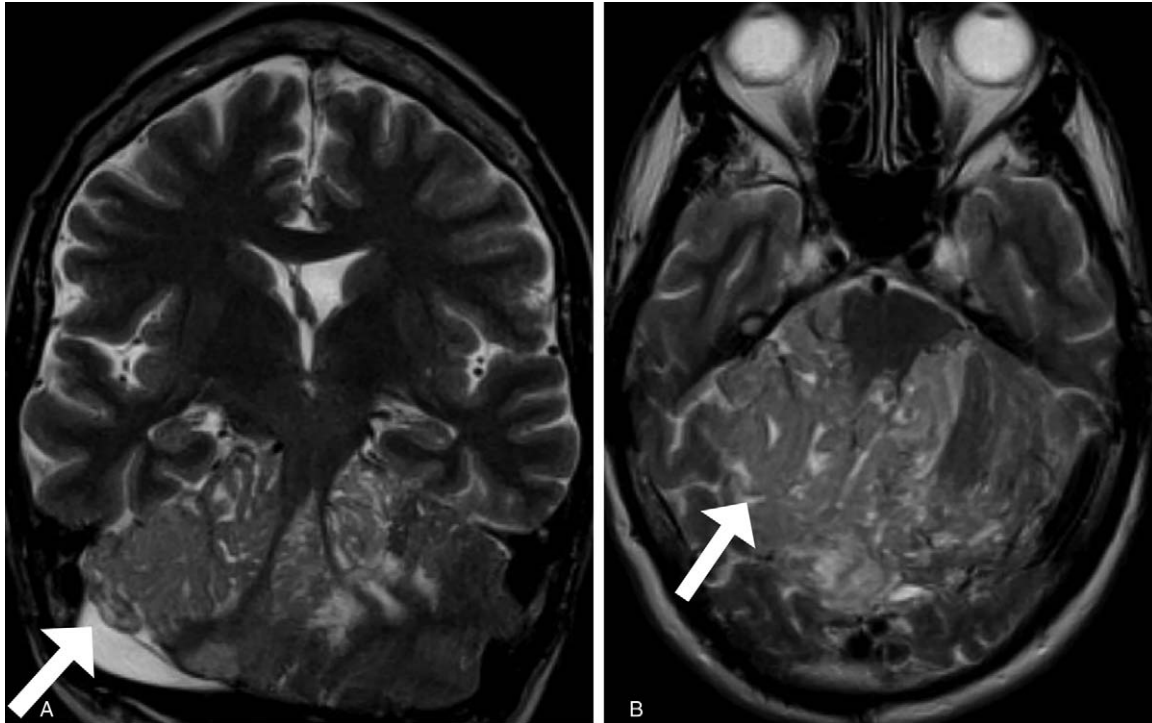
Cowden-Lhermitte-Duclos syndrome. Coronal (A) and axial (B) T2-weighted images show a hyperintense expansile cerebellar lesion with a “tiger-striped” appearance compatible with Lhermitte-Duclos disease (also known as desmoplastic cerebellar gangliocytoma) (white arrows).
